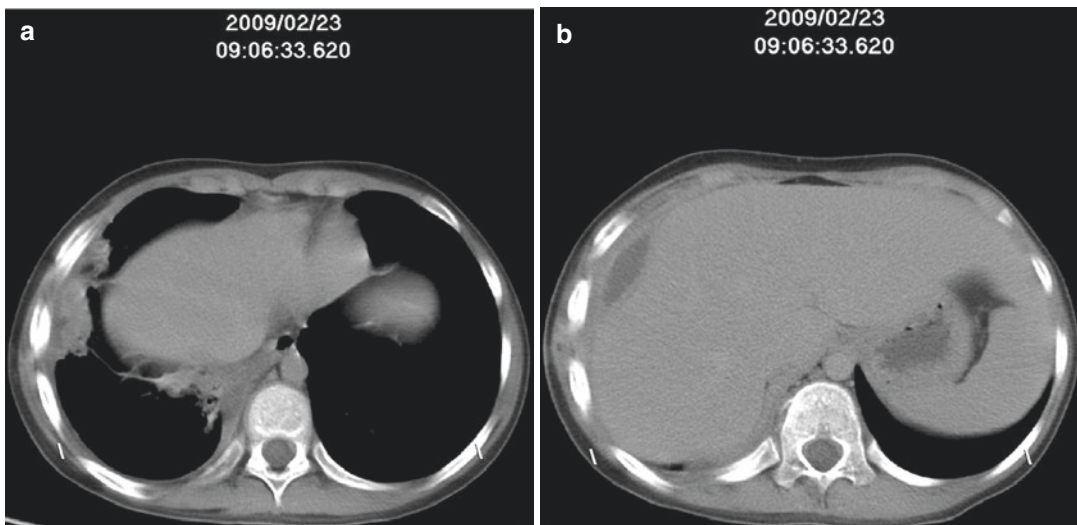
Chest CT during hospitalization, 1 month after antibiotic treatment and drainage surgery in axial (a) and coronal (b) views
